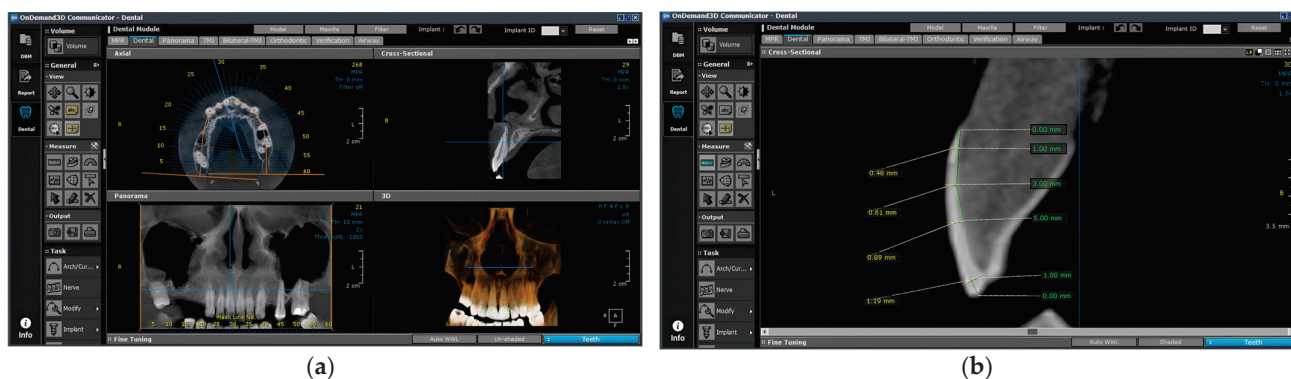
The visualization of the CBCT images: (a) the Dental module of the OnDemand3D communicator software version 1.0 (Cybermed, Daejeon, Republic of Korea); (b) the landmarks used for the measurements.
